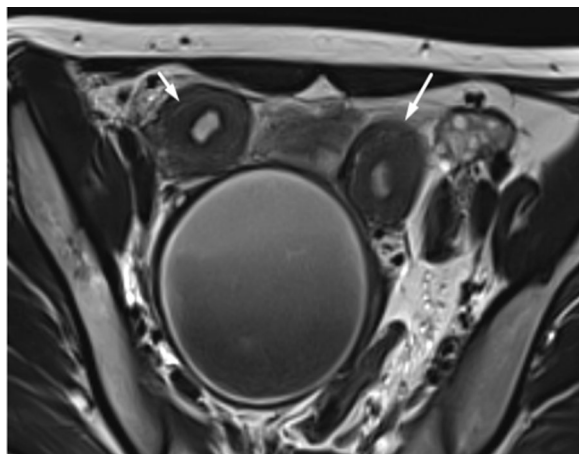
MRI pelvis T2-weighted axial images showing two uterine cavities (arrows)
